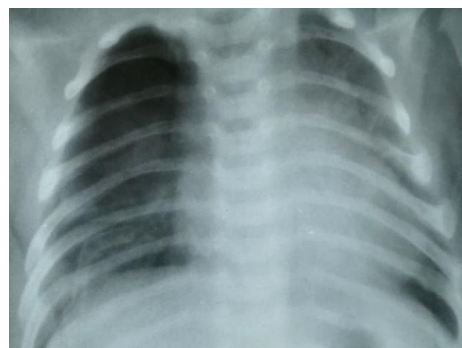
Chest X-ray — partial expansion of the remaining part of the lung after lobectomy with partial atypical resection for right-sided CCAM, patient F.Sh., 1 year 1 month old, case No. 614-52
